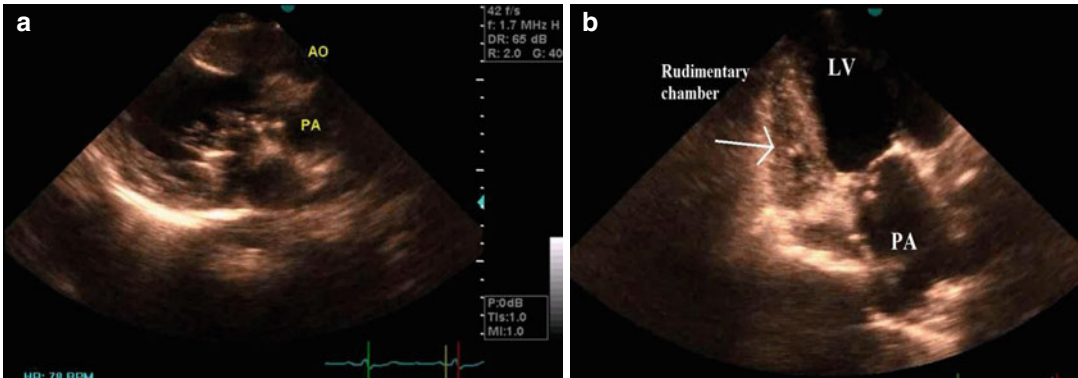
Transthoracic echocardiography in parasternal and apical long axis view showing DILV and transposition of great arteries. *Arrow* indicates rudimentary chamber. *AO* aorta, *PA* pulmonary artery, *LV* left ventricle
